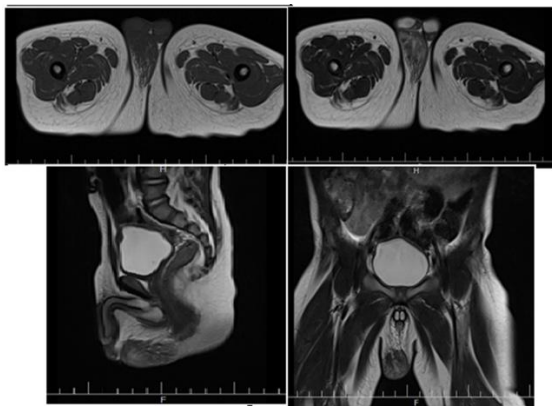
T1 and T2 images of MRI from scrotal mass
